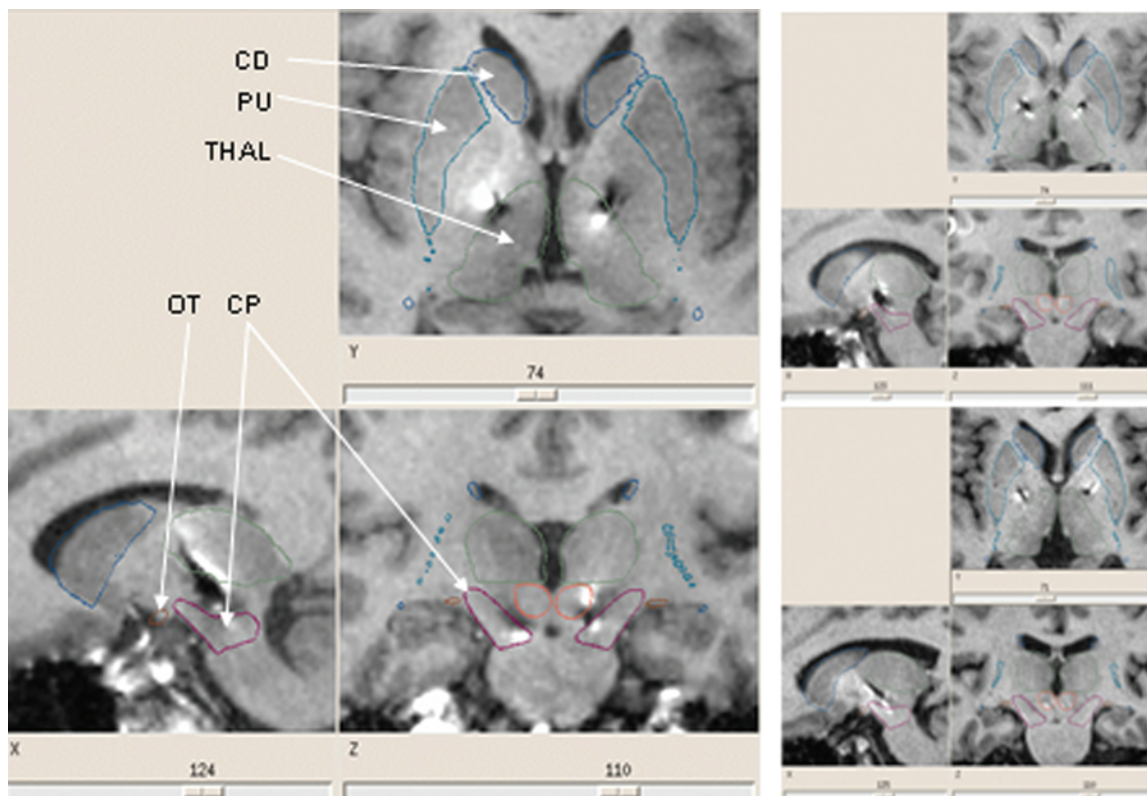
Standardized visual inspection of deformed atlas structures in T1-weighted MR images. Postoperative MR images obtained in 3 patients are shown with superimposed atlas structures. The MR images were resliced along the AC-PC plane together with the contours of atlas structures visible on 3 orthogonal standard planes (sagittal, coronal, and axial): head of the caudate nucleus (CD), anterior and medial part of the putamen (PU), lateral border of the cerebral peduncle (CP), anteroventral part of the optic tract (OT), and medial border of the thalamus including the habenula (THAL). Note the close correspondence between the MR images and the atlas contours.
